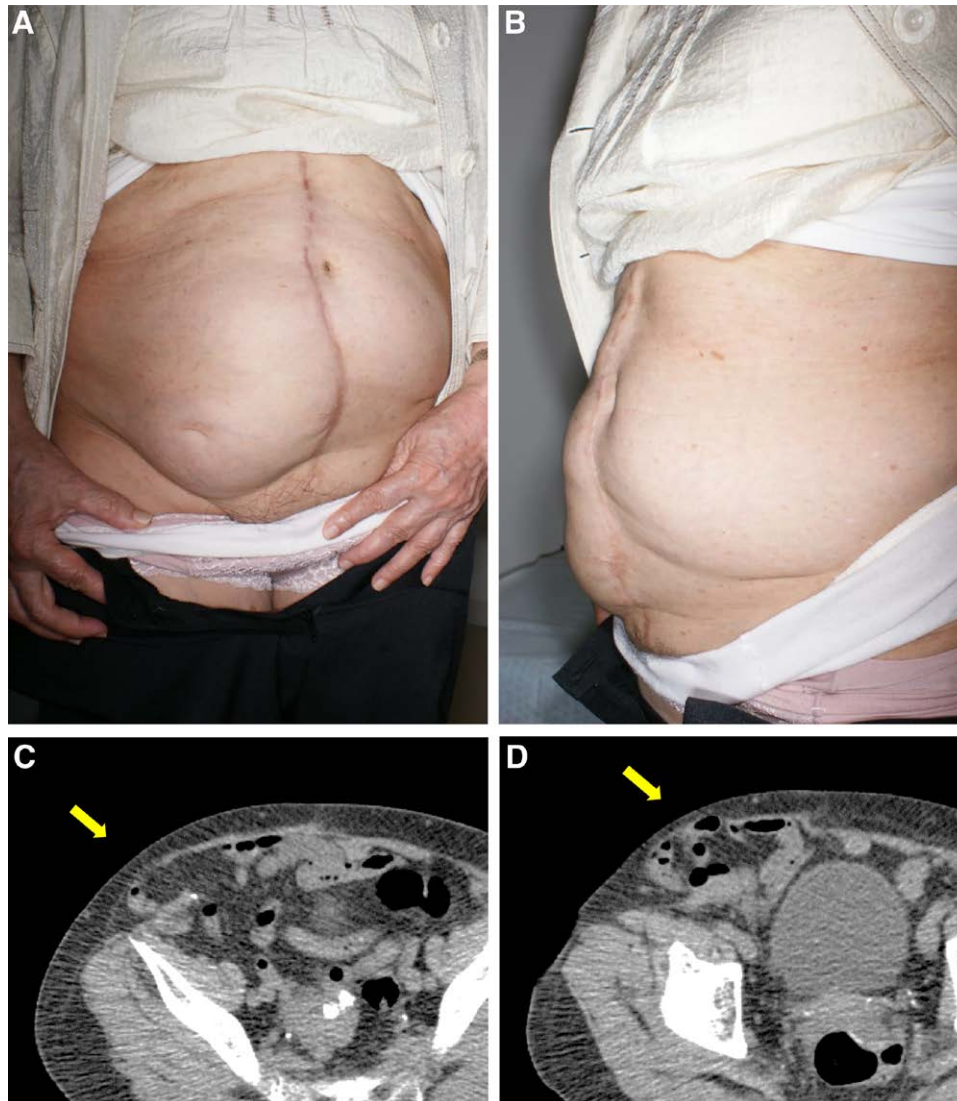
A case of abdominal incisional hernia (No. 4 in Table 3). A, An abdominal incisional hernia in the right abdominal flap donor-site. B, Left lateral view shows that the right abdomen is highly protruded when compared with the left side. C-D, Abdominal computed tomography showing bowel herniation (arrow) from the right abdominal wall.
